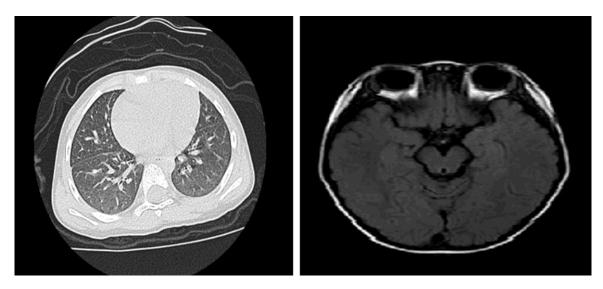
The chest CT scan and cranial MRI were normal after following up 2 more years of case 2.
